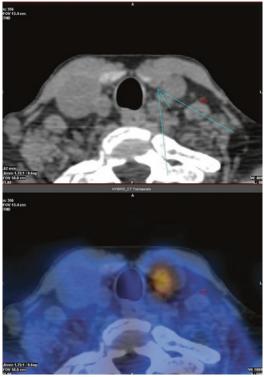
Tc-99m-sestamibi parathyroid SPECT-CT scans showing left inferior lobe parathyroid adenoma
